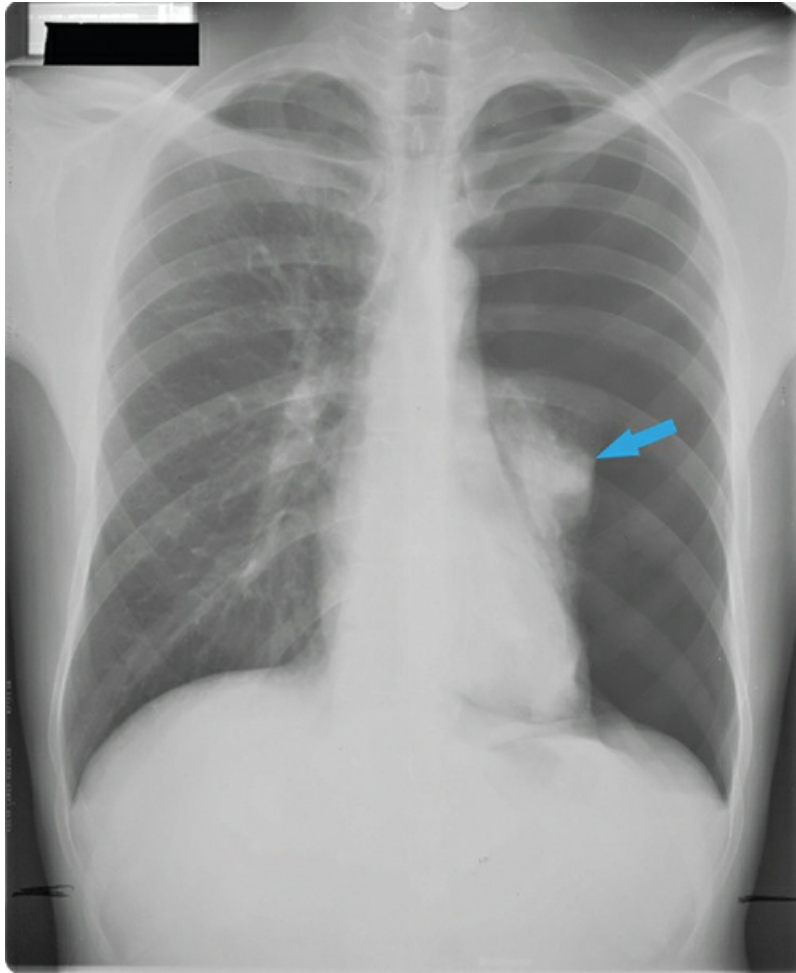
Chest radiograph of left spontaneous pneumothorax.
